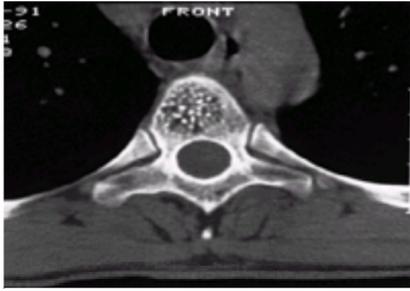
Computed tomography scan of a typical hemangioma of the vertebral body. The small foci of increased density are thickened trabeculae of bone, and the low-density areas are filled with the hemangiomatous tissue.
